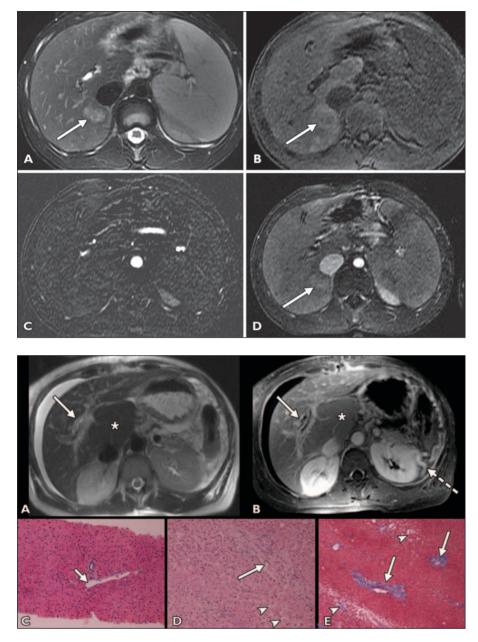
8-year-old boy with hepatoportal sclerosis diagnosed with percutaneous liver biopsy. A–D, Transverse fat-suppressed fast spin-echo T2-weighted (A), fat-suppressed unenhanced (B), and contrast-enhanced subtracted 3D T1-weighted arterial (C) and portal venous phase (D) images show liver with smooth contour, enlarged caudate lobe, and splenomegaly. Right posterior lobe liver lesion (arrows) is T2 hyperintense with hypointense rim, slightly T1 hyperintense, and enhancing in portal venous phase. Patient had another lesion with same signal intensity and enhancement characteristics in right anterior lobe (not shown). Both lesions had decreased in size at 18-month follow-up MRI (not shown).
